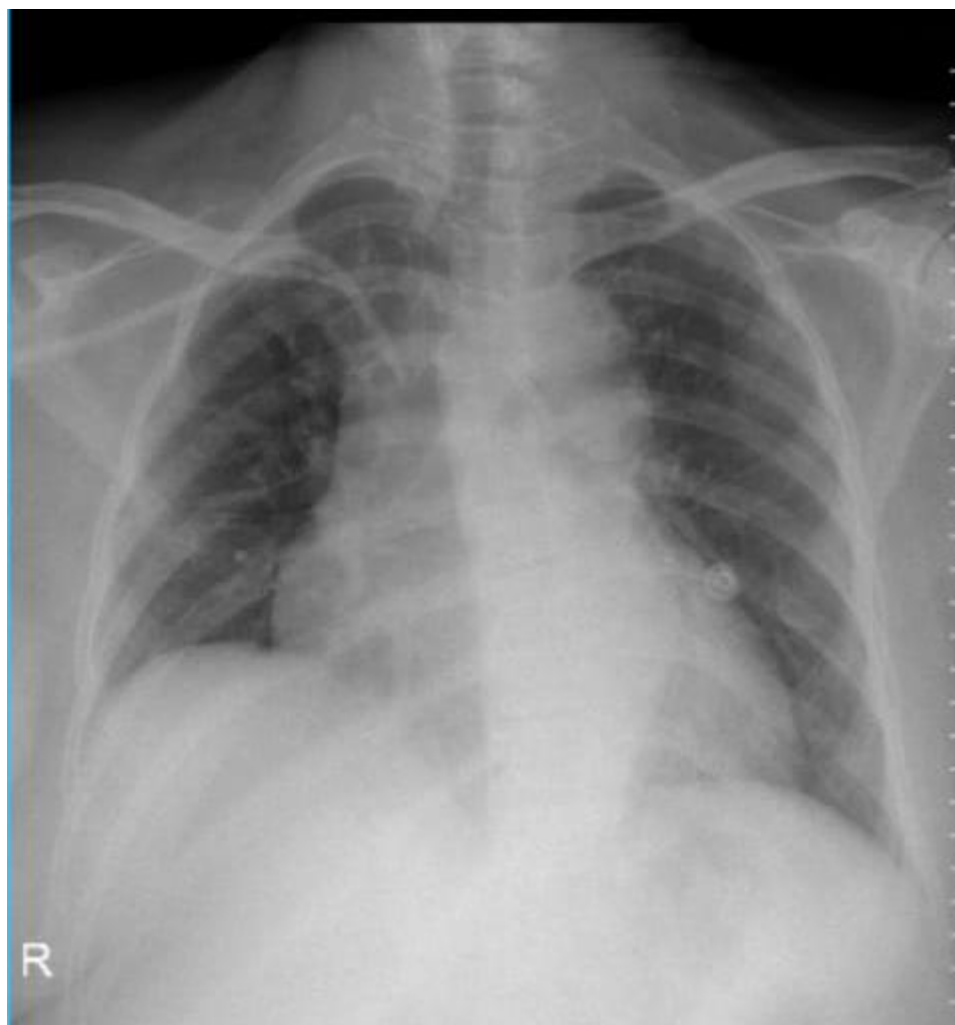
Roentgen of thorax showed cardiomegaly with congestive lung.
